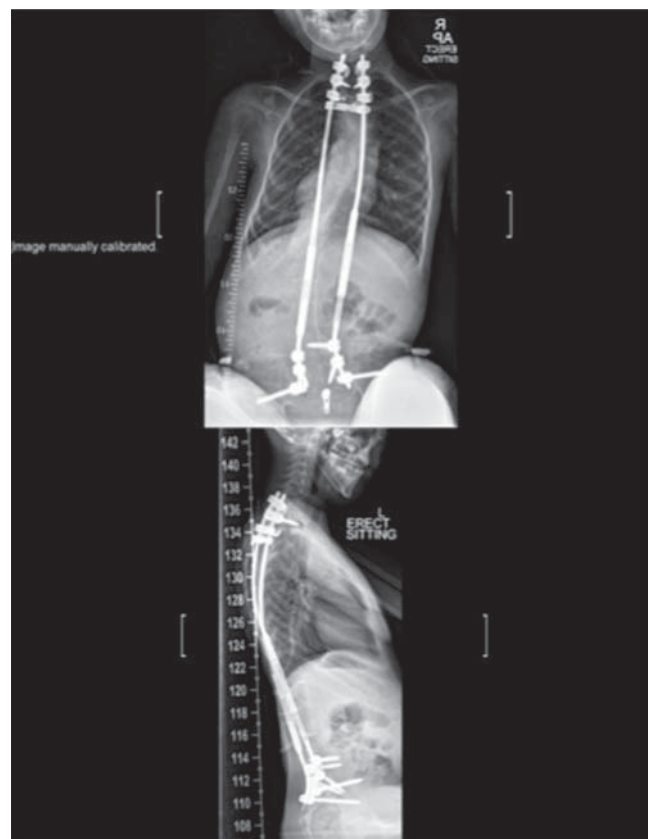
AP and lateral radiographs at seventh distraction—26 months. AP indicates anteroposterior.
